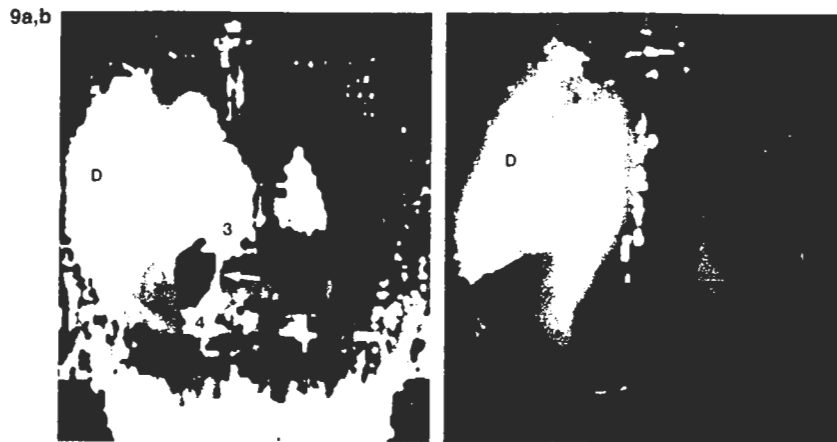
3D noncontrast CT scans show unilateral open-lip schizencephaly in a 7-month-old girl. Posterior (a) and superior (b) views demonstrate right hemiatrophy with smaller right hemicalvarium and a larger right lateral ventricle that communicates broadly with a wide fan-shaped diverticulum (D) in the general region of the island of Reil and the sylvian fissure. The interhemispheric fissure is widened on each side of the falx. The posterior third ventricle (3), aqueduct (white arrow), and fourth ventricle (4) are also seen in (a).
